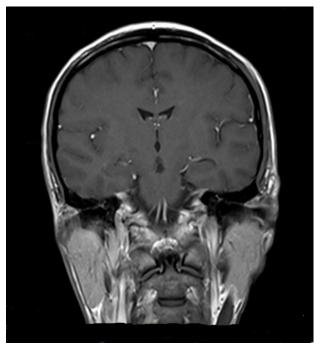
(a) Axial T2 and (b) T1 post contrast showed an ill-defined lesion at right temporal which is hypointense on T1, hyperintense on T2, not suppressed on fluid attenuated inversion recovery (FLAIR) suggestive of temporal encephalitis or cerebritis
